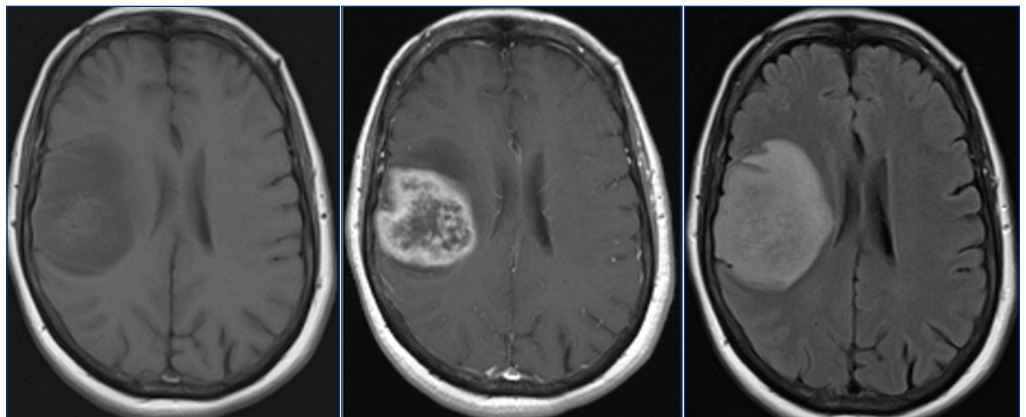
[A] Non-contrast enhanced T1-weighted imaging of the brain demonstrates a hypointense lesion in the right frontotemporal brain. [B] Post-contrast T1-weighted imaging demonstrates predominantly peripheral enhancement of the right frontotemporal lesion. [C] Axial T2-weighted fluid-attenuated inversion recovery imaging (FLAIR) demonstrates hyperintense signal associated with right frontotemporal lesion with mass effect resulting in right to left midline shift and effacement of the right lateral ventricle.
